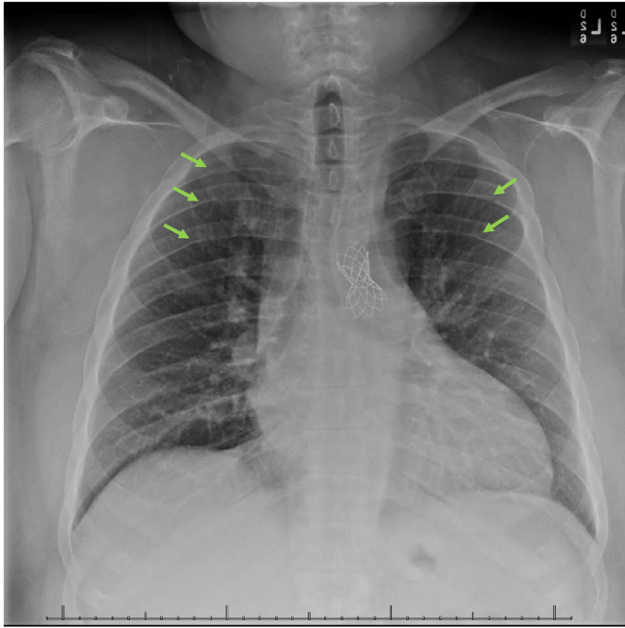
Chest x-ray, anterior-posterior view, demonstrates rib notching (arrows) from the hemodynamically significant CoA with a robust network of intercostal collateral vessels.
